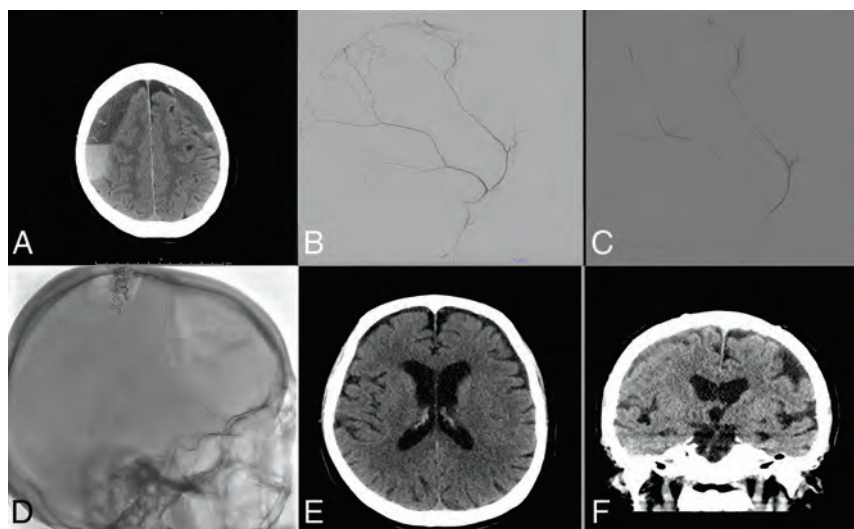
Treatment course of a 77-year-old man with bilateral cSDH. Noncontrast axial head CT reveals bilateral subacute-on-chronic SDHs on admission (A). Diagnostic cerebral angiogram reveals robust filling of the MMA (B). The MMA was then embolized using *n*-BCA diluted with D5W (C). Postprocedural spin sequence reveals the glue cast left in the MMA (D). Noncontrast head CT at 3 months reveals significant resolution of the patient's SDHs (E and F).
